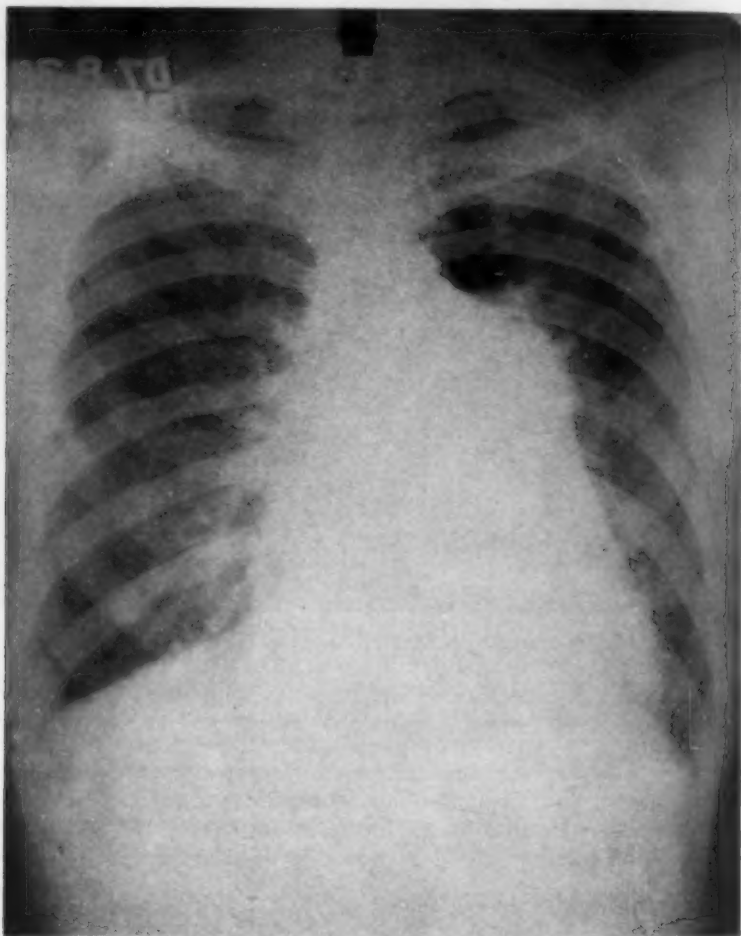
Roentgenogram of the chest with findings similar to those seen on admission to Cardiac Service in March 1936, showing pulmonary conus abnormality which suggested "aneurysm" or "congenital heart."
